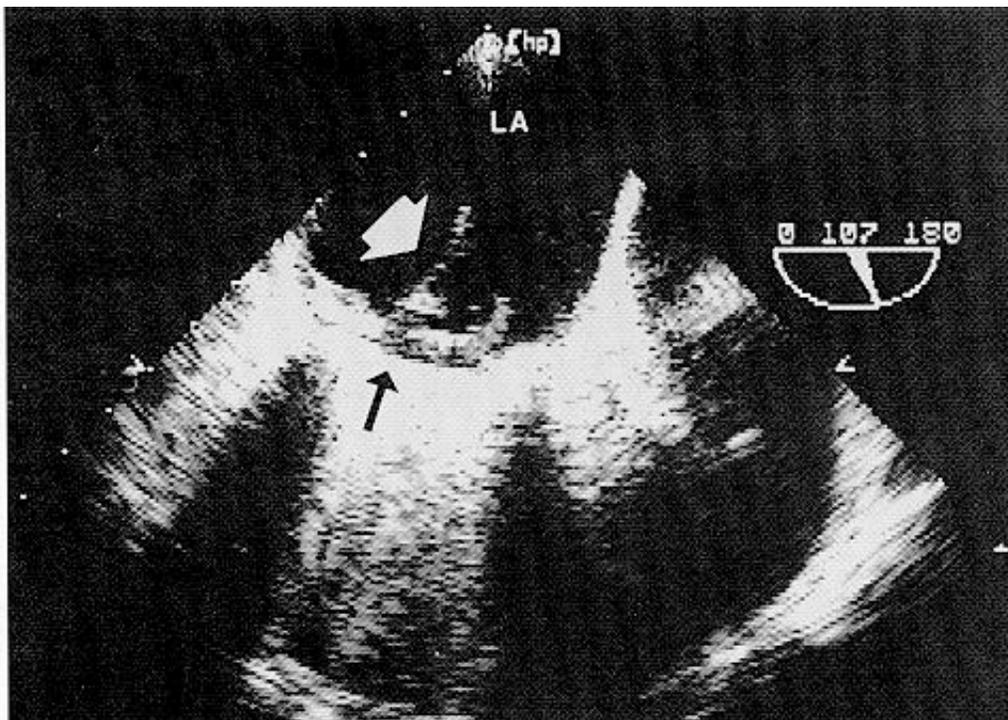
Vegetation (*white arrowhead*) on left atrial aspect of mechanical mitral prosthesis. Reverberation artifact (*black arrow*) obscures detail distal to prosthesis, and precludes visualization of vegetation from transthoracic windows.
